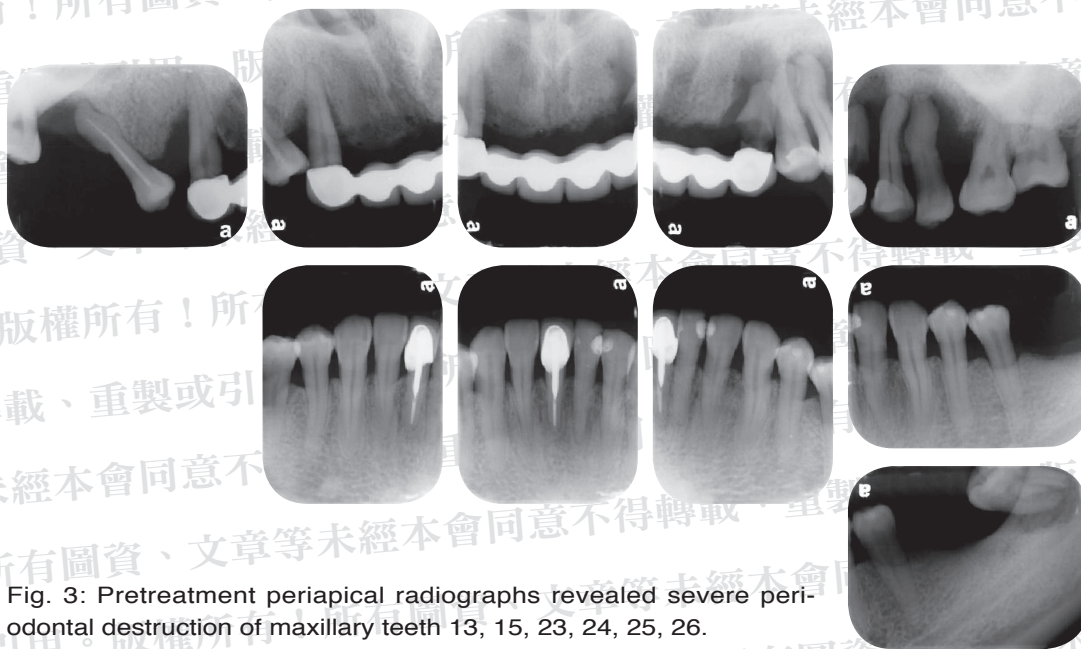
Pretreatment periapical radiographs revealed severe periodontal destruction of maxillary teeth 13, 15, 23, 24, 25, 26.
